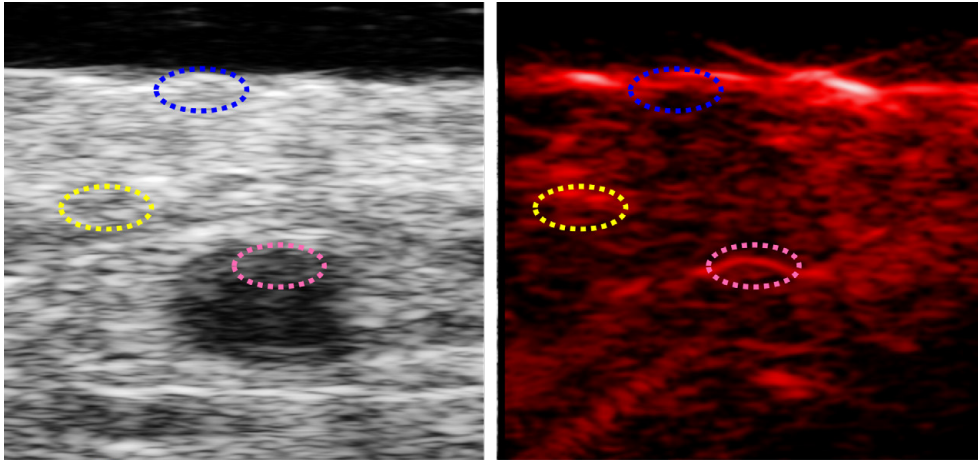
Representative examples of an ultrasound image (left) and a photoacoustic image (right) of a cross-section of the temporal artery. Regions of interest used for spectral analysis are shown on the artery wall (pink), the skin (blue), and the subcutaneous tissue (yellow).
